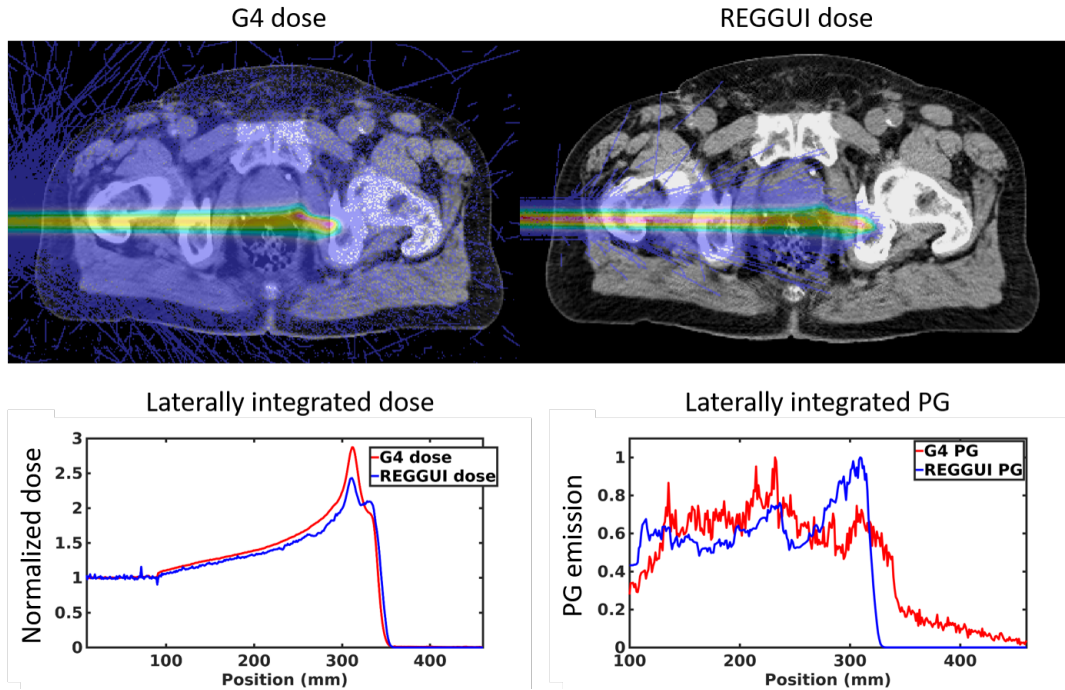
The axial slice of the 3D dose distribution in colourwash superimposed onto the grayscale CT (top) as well as laterally integrated depth dose (bottom left) and PG (bottom right) profiles of a PB passing through tissue heterogeneities, as calculated by Geant4 (top: left panel; bottom: red lines) and REGGUI (top: right panel; bottom: blue lines).
